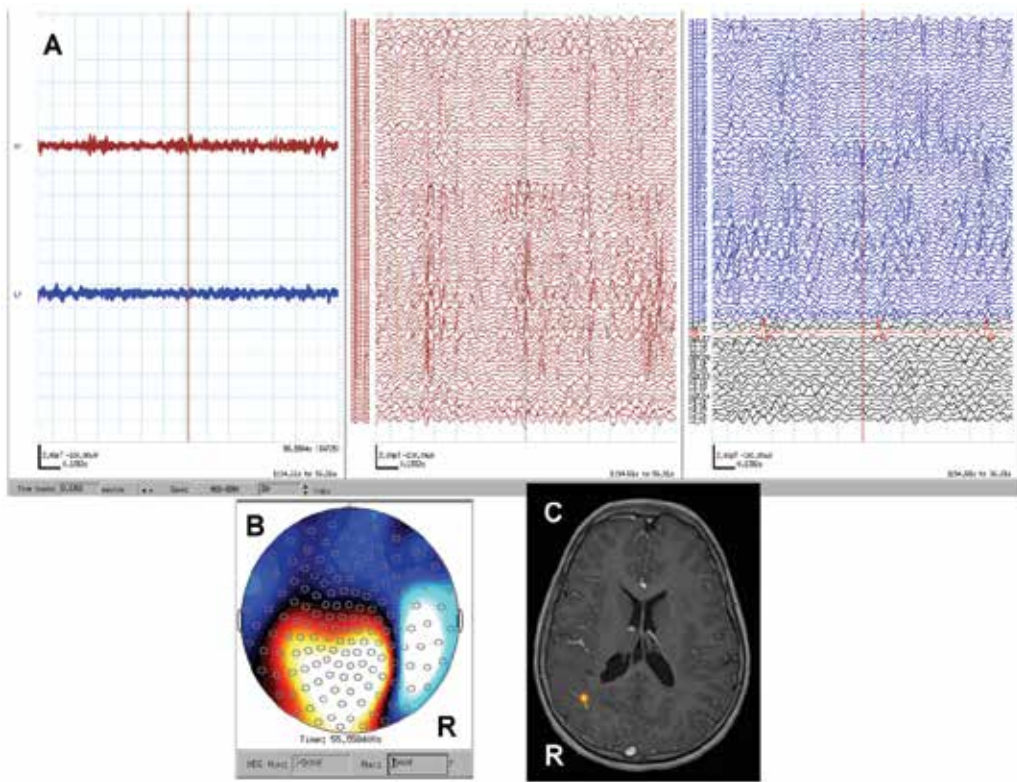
Deep MEG dipoles without simultaneous EEG spike. A, MEG shows a red cursor at right hemispheric MEG spikes. B, Magnetic field topography shows tight sink and source at the MEG spike peak. C, Single moving dipole analysis shows an MEG dipole in the right temporo-parietal subcortical abnormality on axial MRI.
